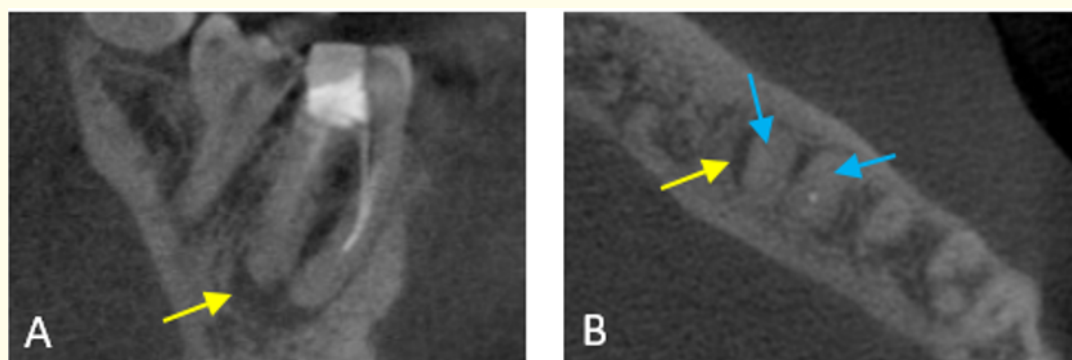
Cone beam computed tomography tooth #46. (A) Sagittal plane shows a radiolucency related to tooth #46 (yellow arrow). (B) axial view demonstrate root canal filling does not reach to apical area in mesiobuccal root and distal root (blue arrow).
